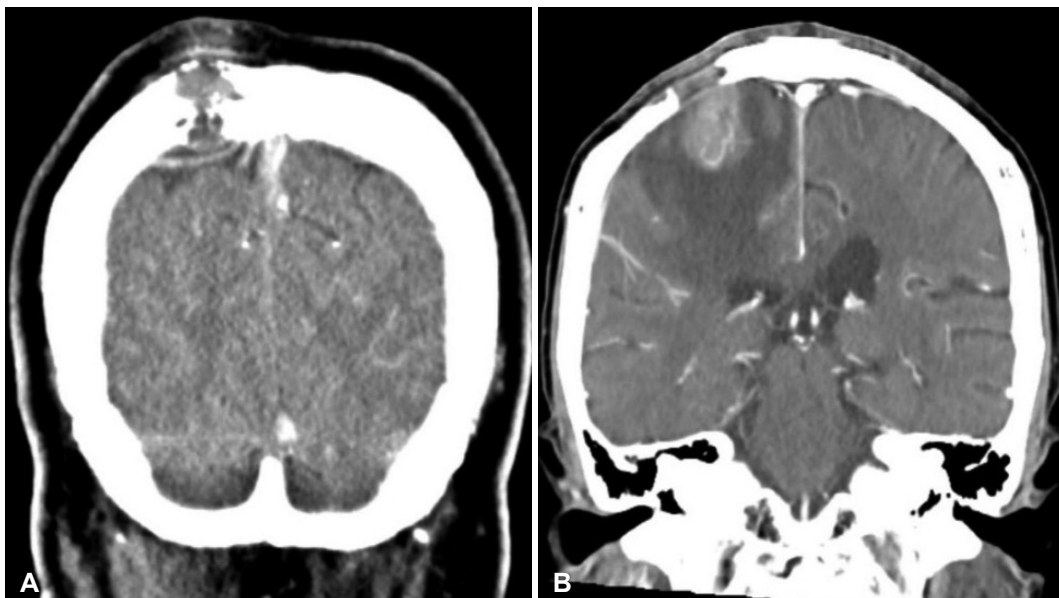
Comparative CT scans. Both A and B have osteolytic skull lesions at right parietal area. A: The tumor has a broad calvarial base, more expansion of the soft tissue. B: The tumor has a broad dural base, brain edema and more expansion of the brain parenchyma.
